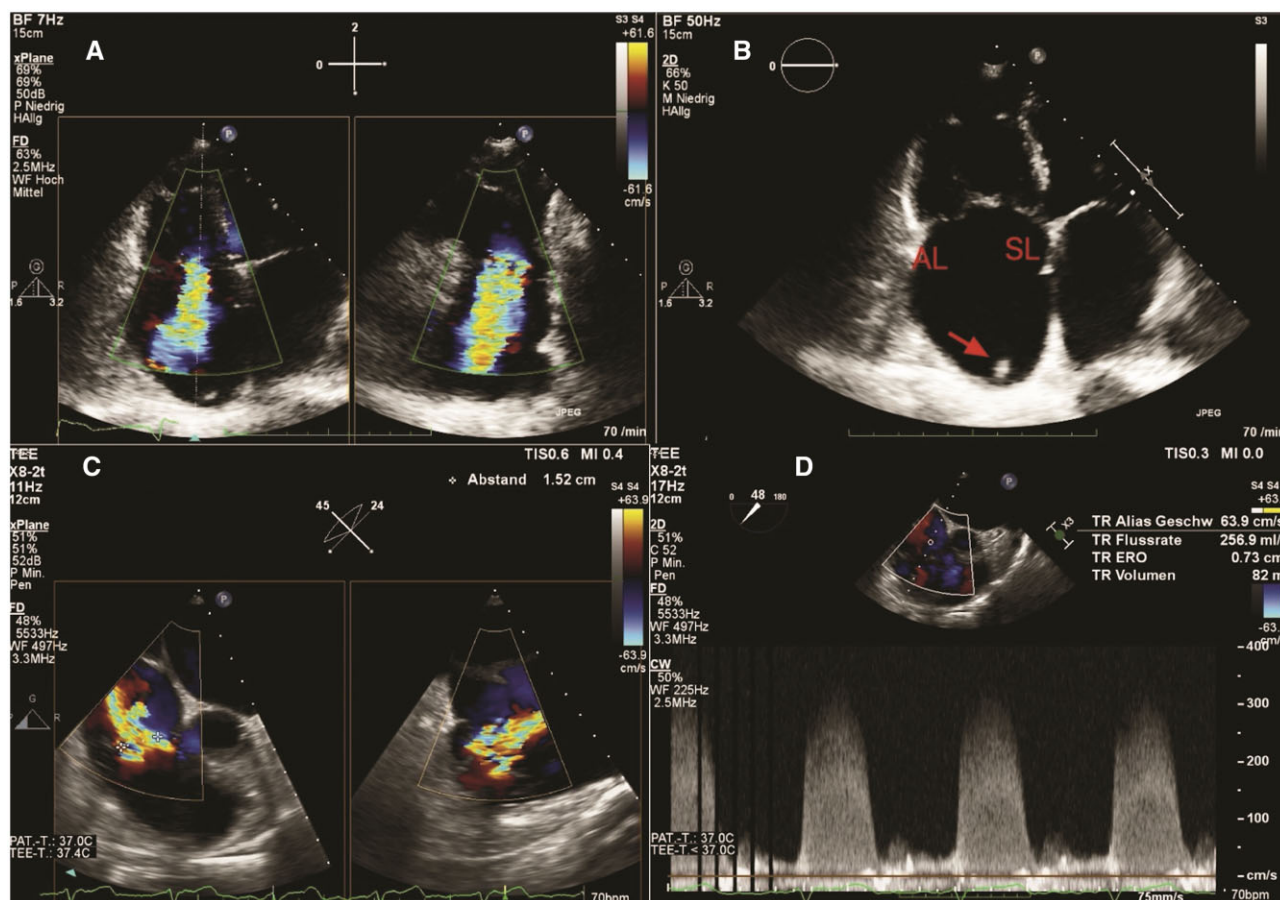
Preprocedural echocardiographic evaluation showing massive tricuspid regurgitation. (A) Transthoracic echocardiography bi-plane, colour flow Doppler, four- and two-chamber view of the right heart. (B) Four-chamber view. AL, anterior leaflet; Arrow, pacemaker lead; SL, septal leaflet. (C) Transoesophageal echo bi-plane views of tricuspid valve. (D) Continuous wave Doppler assessment of tricuspid regurgitation.
